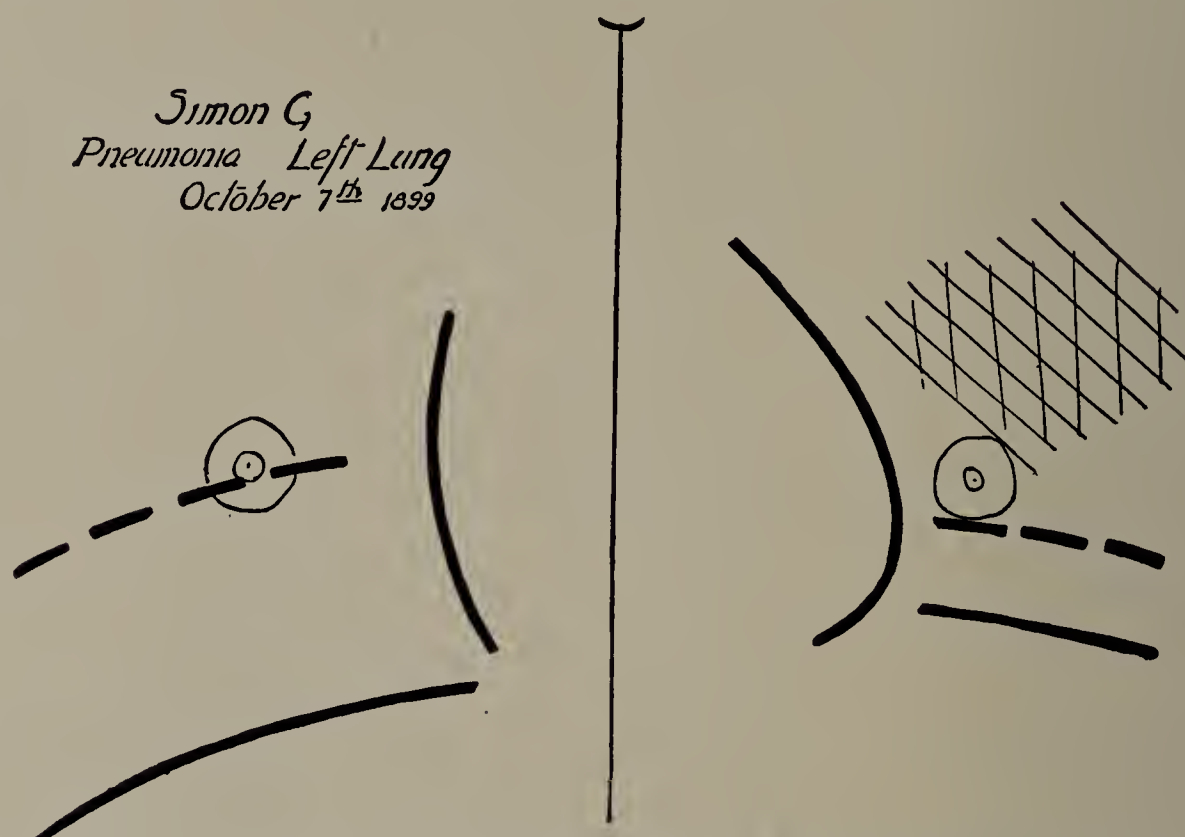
Simon G. October 7. Cut of second X-ray tracing. Shaded area diminished; movement of diaphragm increased on both sides. (One-third life size.)
